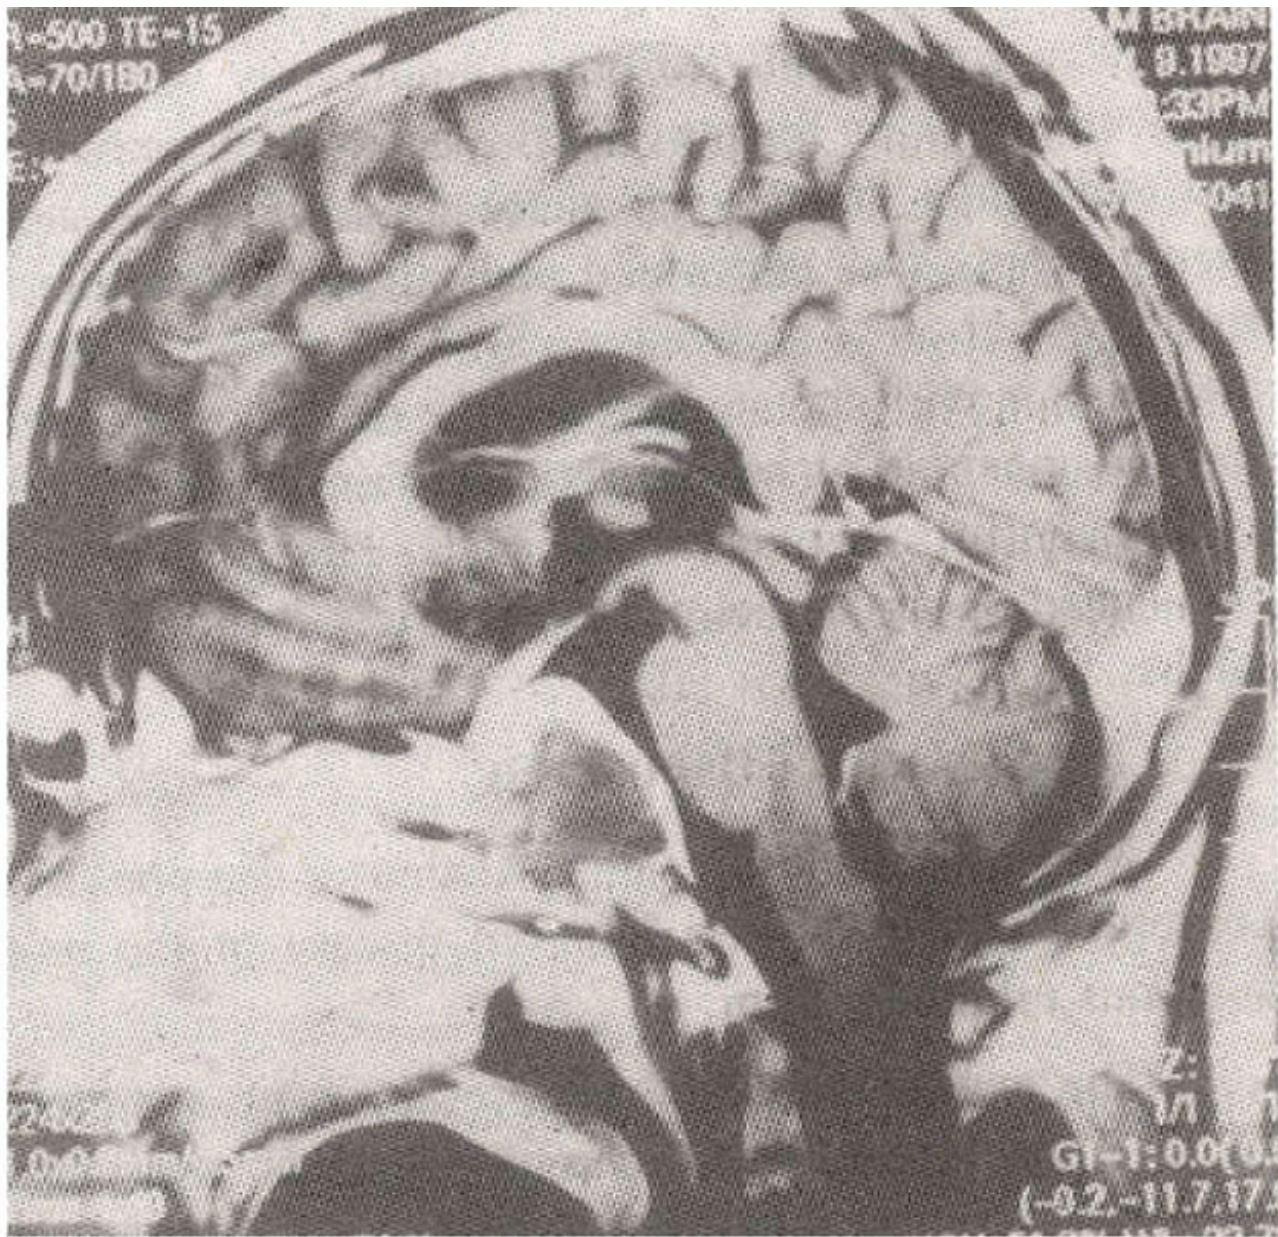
MRI (Sagittal) with gadolinium showing the mass as hypodense signal on T2 weighted image.
